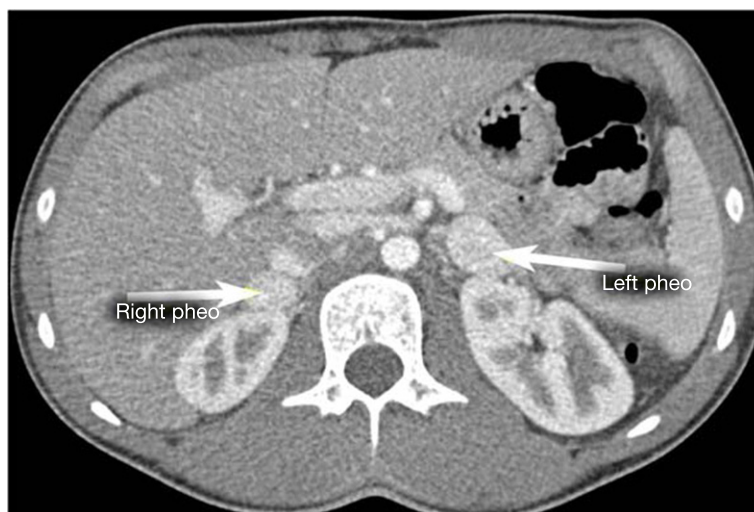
Computed tomography with intravenous contrast shows enhancing bilateral pheochromocytomas in a patient with MEN2A due to a germline *RET* mutation in codon 634.
